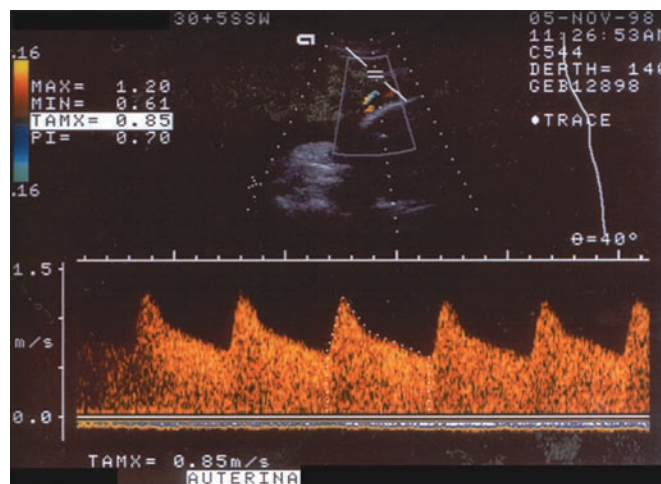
Normal Doppler FVW of uterine artery in the third trimester.
